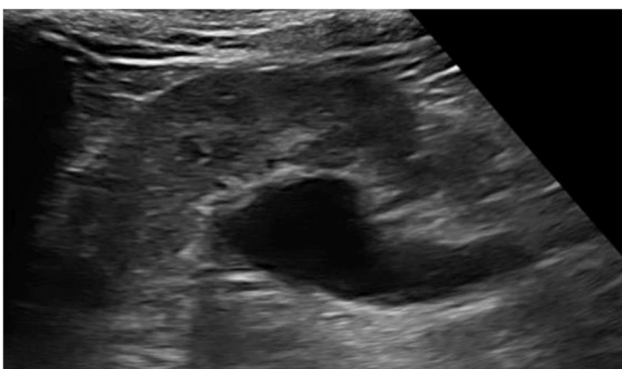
US abdomen image (longitudinal view) showing proximal left hydroureter. US, ultrasound.
